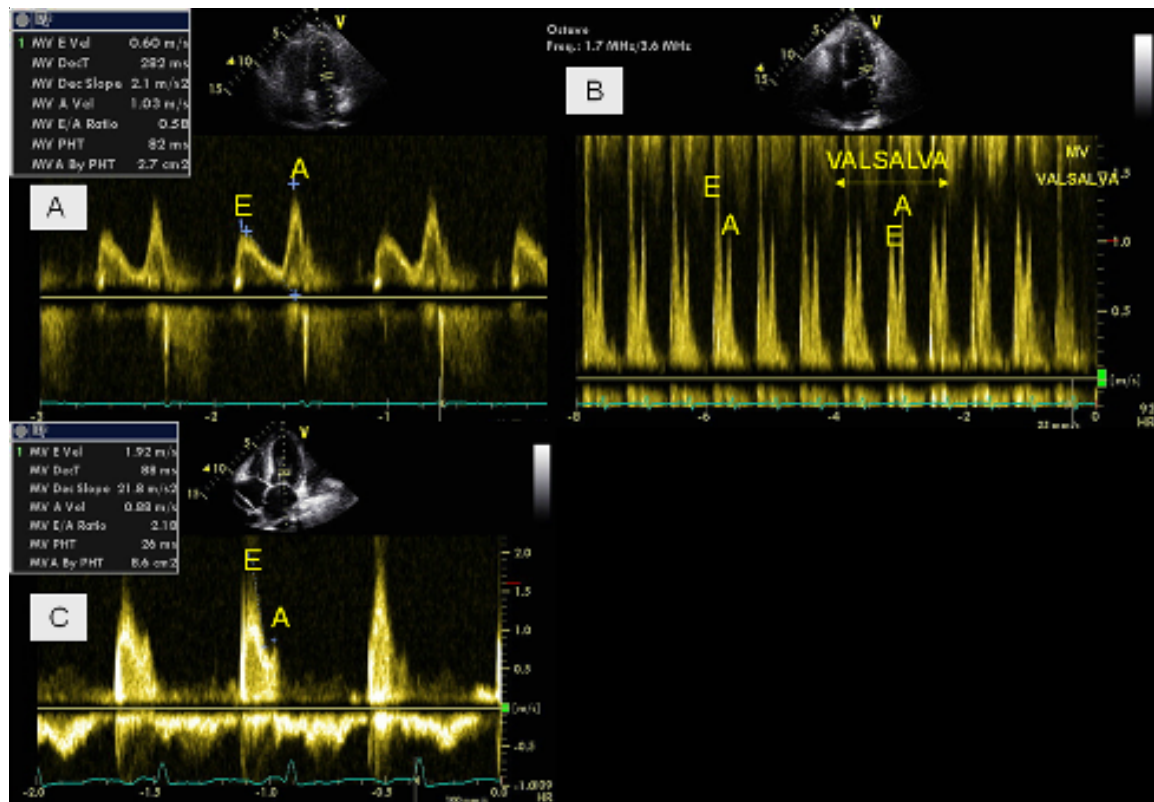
The severity of diastolic dysfunction can be assessed using Doppler and tissue Doppler imaging echocardiography. (A) Mild diastolic dysfunction or abnormal left ventricular relaxation, where there is reversal of the ratio of early diastolic flow velocity (E wave), atrial contraction (A wave) ($E/A < 1$). (B) Moderate diastolic dysfunction or “pseudonormalization” occurs with an E/A of 1:1.5; a reduction in preload with the Valsalva maneuver can change a pseudonormalized pattern to an abnormal relaxation pattern, or a restrictive pattern to a pseudonormalized one. (C) Severe diastolic dysfunction or restrictive filling is defined when $E/A > 2$.
